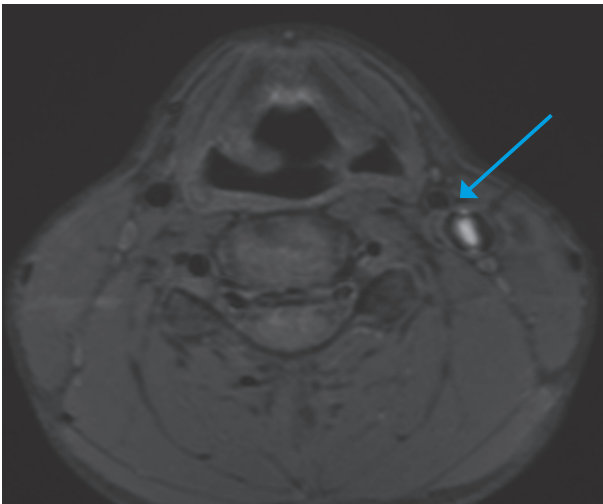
Axial T1-weighted magnetic resonance image shows intraluminal thrombus in the left common carotid artery
